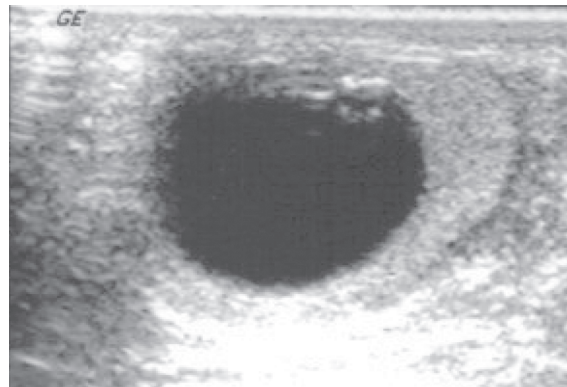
Ultrasound image shows an anechoic cystic mass in the testis and surrounding thinned but normal testicular parenchyma.
